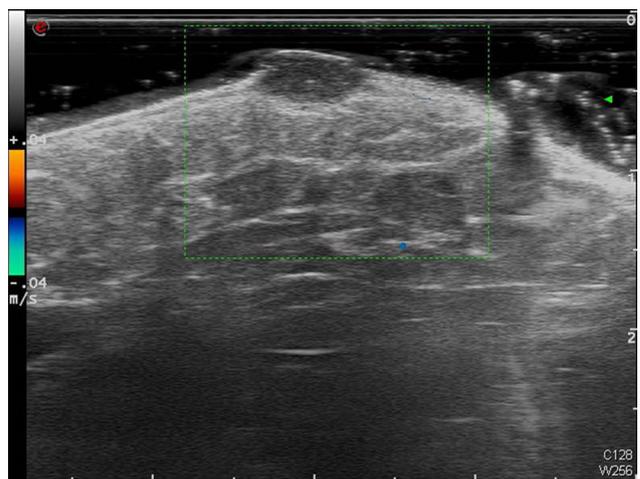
High-frequency (18 MHz) Doppler ultrasound image showing a well-defined, homogeneous, hypoechoic lesion measuring 6.5 × 3.5 mm in the dermis, with no blood flow internally.
